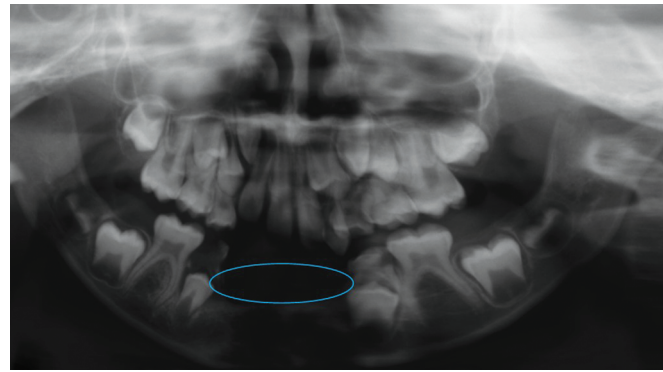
Orthopantomogram showing oligodontia in a 14-year-old male patient suffering from neuroblastoma
